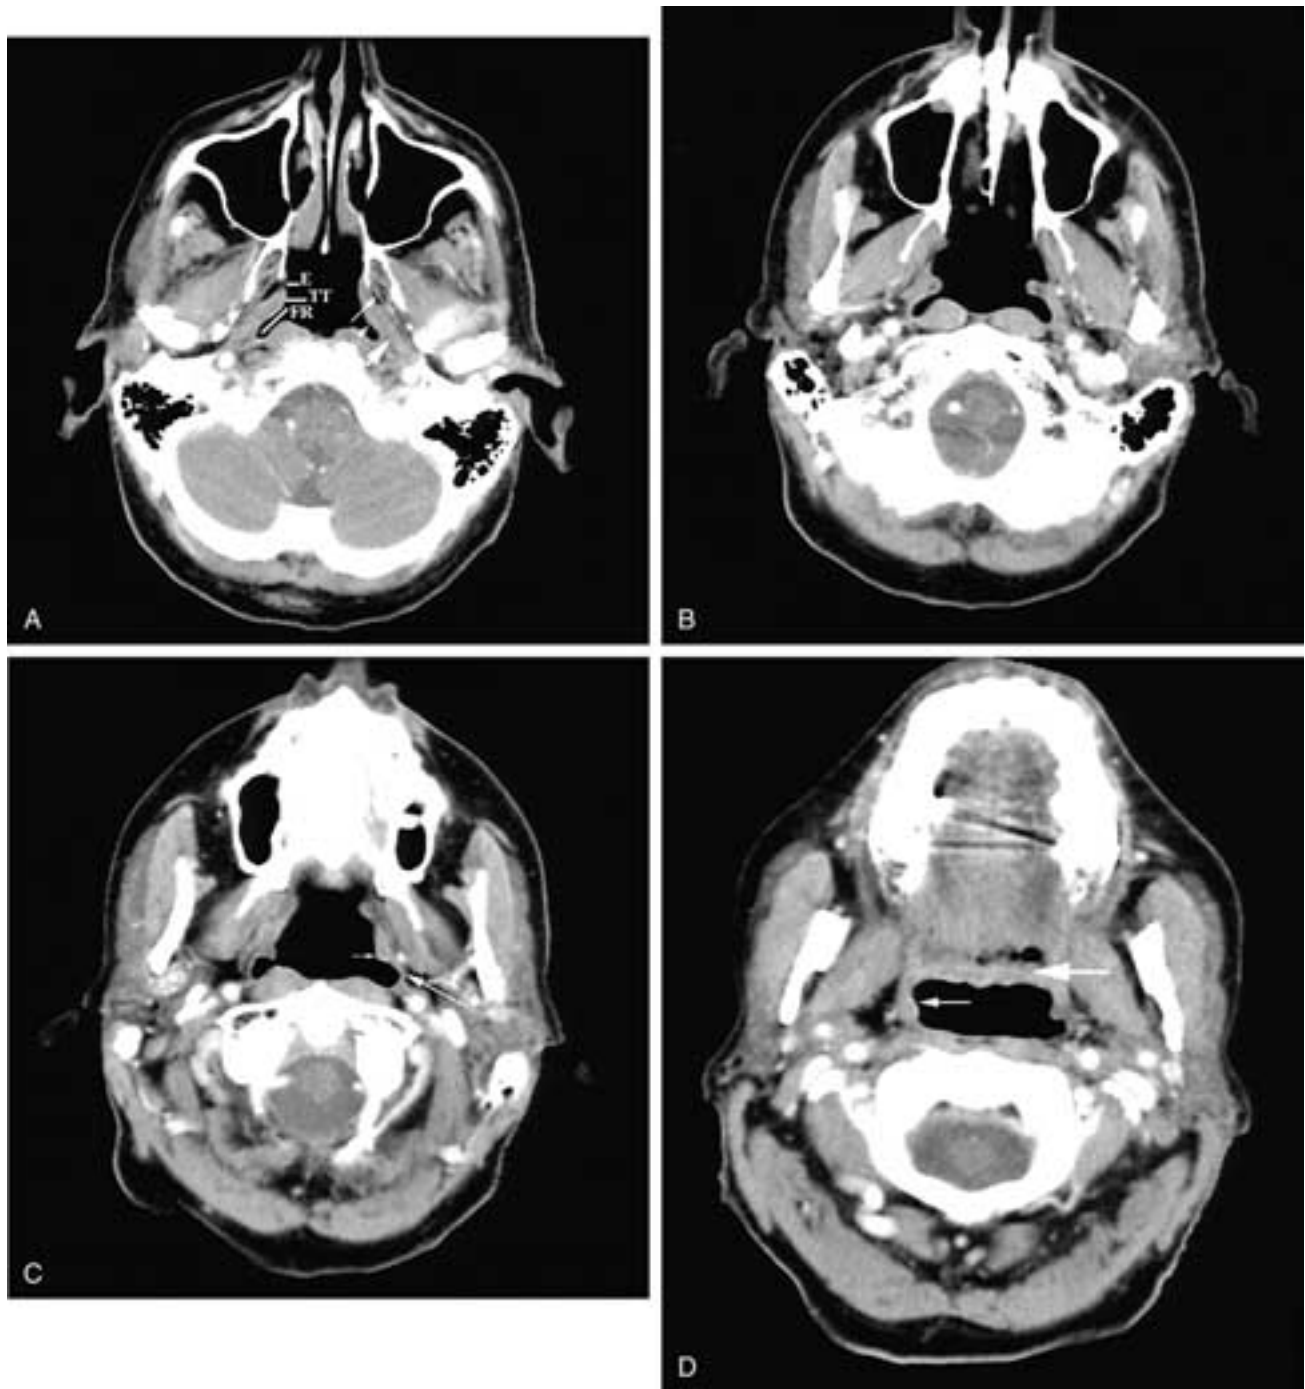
Axial sequential contrast-enhanced CT scans extending from cranially (A) to caudally (D). In A, the fossa of Rosenmueller (FR), the torus tubarius (TT), and the opening of the eustachian tube (E) are shown. The tensor veli palatini muscle (*small arrow*) is seen lateral to the pharyngeal constrictors (*arrowhead*). The tensor muscle remains outside the pharynx until its tendon extends around the hamulus of the medial pterygoid plate to reach the soft palate. The levator veli palatini muscle (*large arrow*) is seen extending from the skull base to lie within the pharyngeal constrictors. In B, the levator veli palatini muscle is seen extending caudally from the torus tubarius. In C, the tapering levator veli palatini muscle (*small arrow*) is seen within the pharyngeal constrictors (*large arrow*). In D, the caudal levator veli palatini muscle (*small arrow*) is seen heading toward the soft palate (*large arrow*), all within the pharyngeal constrictors.
